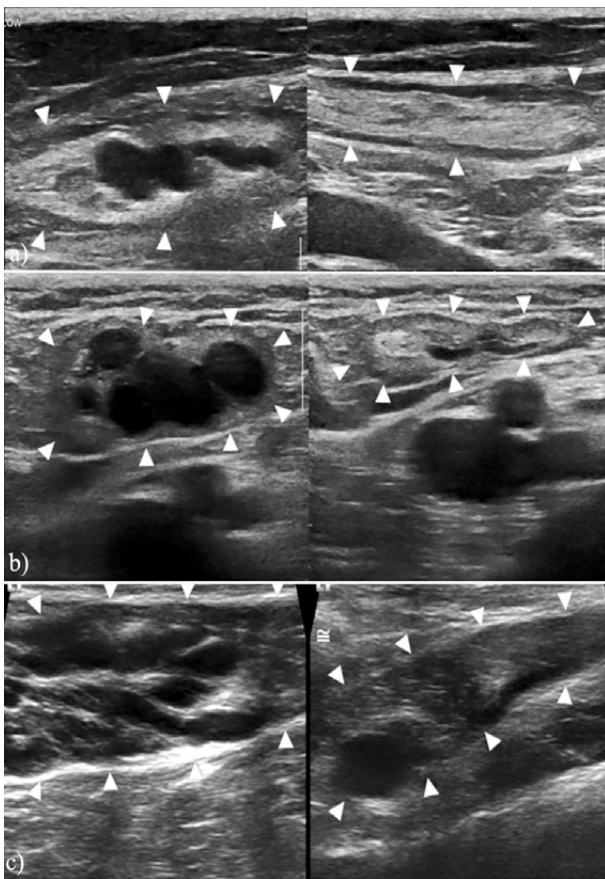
Ultrasound aspect of the infrainguinal lymph node varicose veins, without (left) and with transducer compression (right): a) Lymph node with a mildly dilated hilar vein, with visible echogenic hilum (grade I); b) Lymph node with moderately dilated veins filling the hilum, absent echogenic hilum (grade II); c) Lymph node with markedly dilated veins, with abnormal morphology, spontaneously unrecognizable lymph node and incomplete emptying of the varices with transducer compression (grade III). The white arrowheads point to the lymph nodes in each case.
